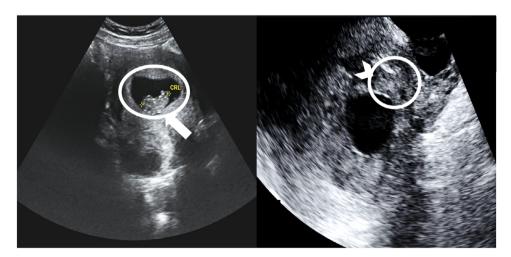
Ultrasonography revealed an intrauterine gestational sac with a fetal pole measuring 24.9 mm in crown-rump length, accompanied by a discernible fetal heartbeat (arrowhead) and an extra-ovarian mass over left adnexal region (arrow and circle).
